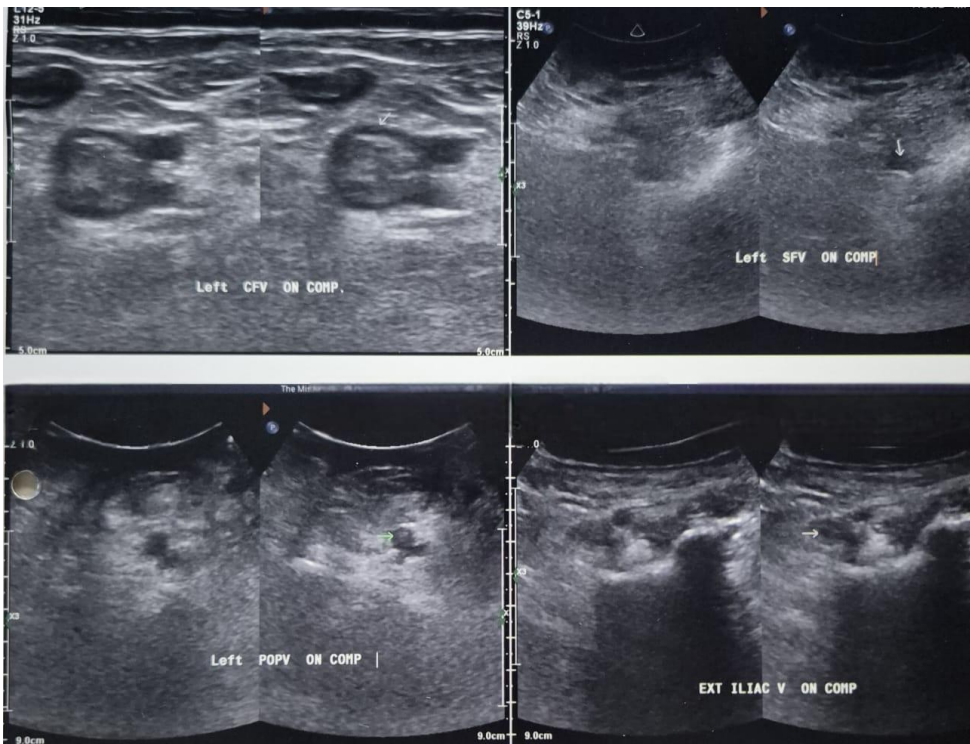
Duplex Doppler and compression ultrasound show loss of compressibility in the common femoral vein, superficial femoral vein, popliteal vein, external iliac vein, and posterior tibial vein, indicating extensive deep vein thrombosis.
